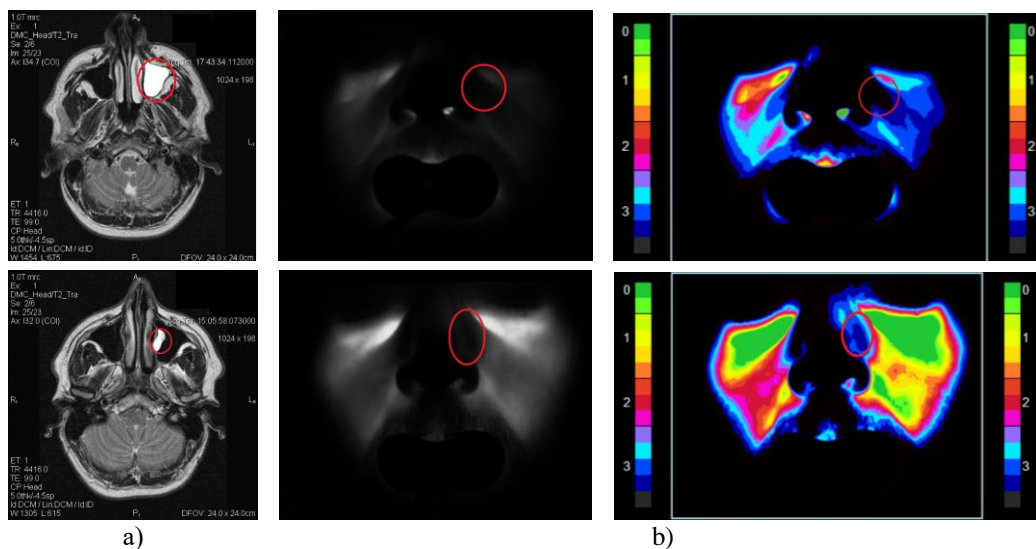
The T2 weighted image by MRI (a) and registered and processed images by diaphanoscopy for patient 1 (top) and patient 2 (bottom) for near-infrared (b) radiation source
